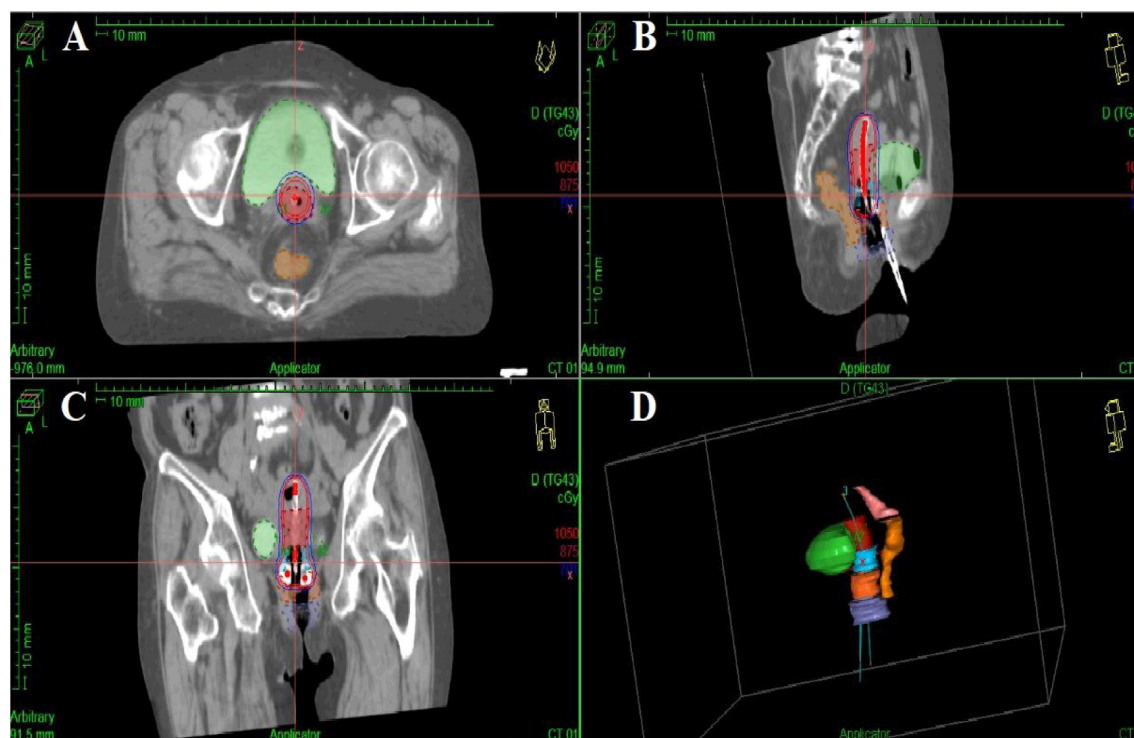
Figure showing axial, sagittal and coronal isodose distributions applicators: A: in the axial plane for TO; B: in the sagittal plane for TO; C: in the coronal plane for TO; D: Target and critical organ contouring for TO (CT guided volume determination and application).
